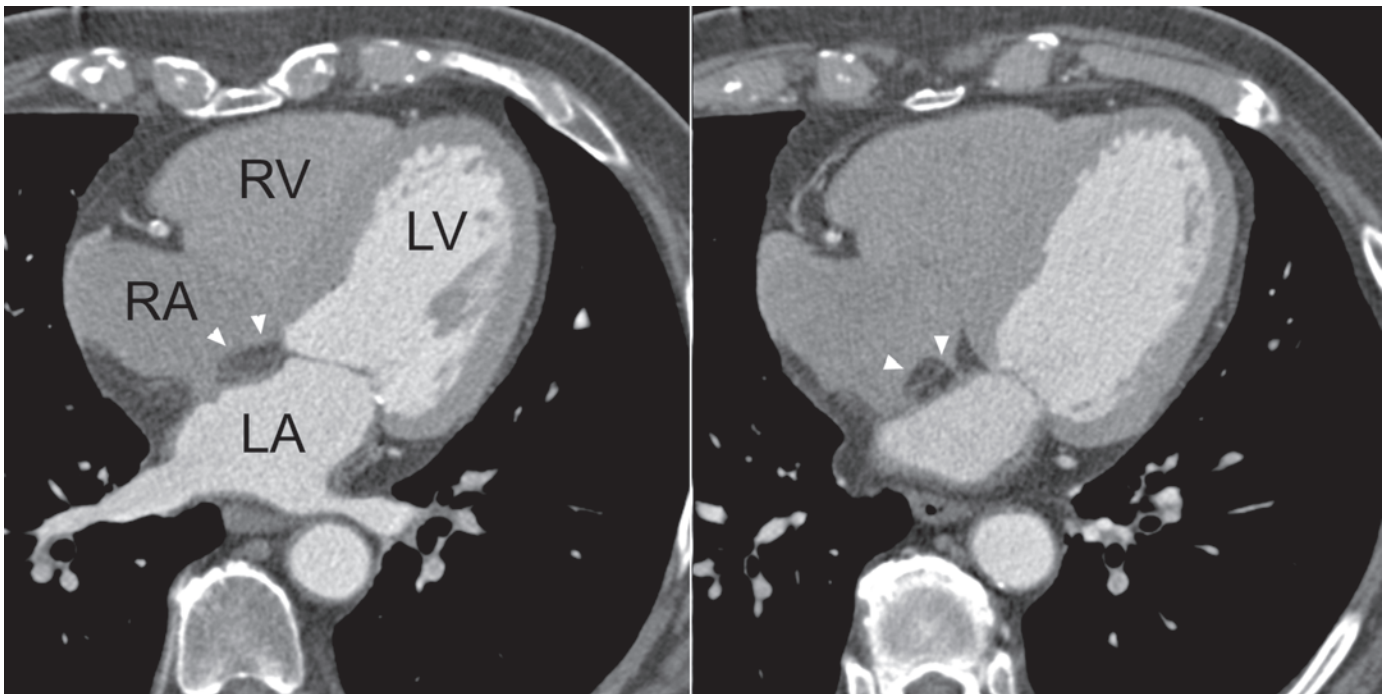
Axial multidetector-row CT images of a patient with lipomateous hypertrophy of the atrial septum. Note the thickened septum and the low-density mass between both atria, consistent with fatty tissue (arrow heads). RA, right atrium; LA, left atrium; RV, right ventricle; LV, left ventricle.
